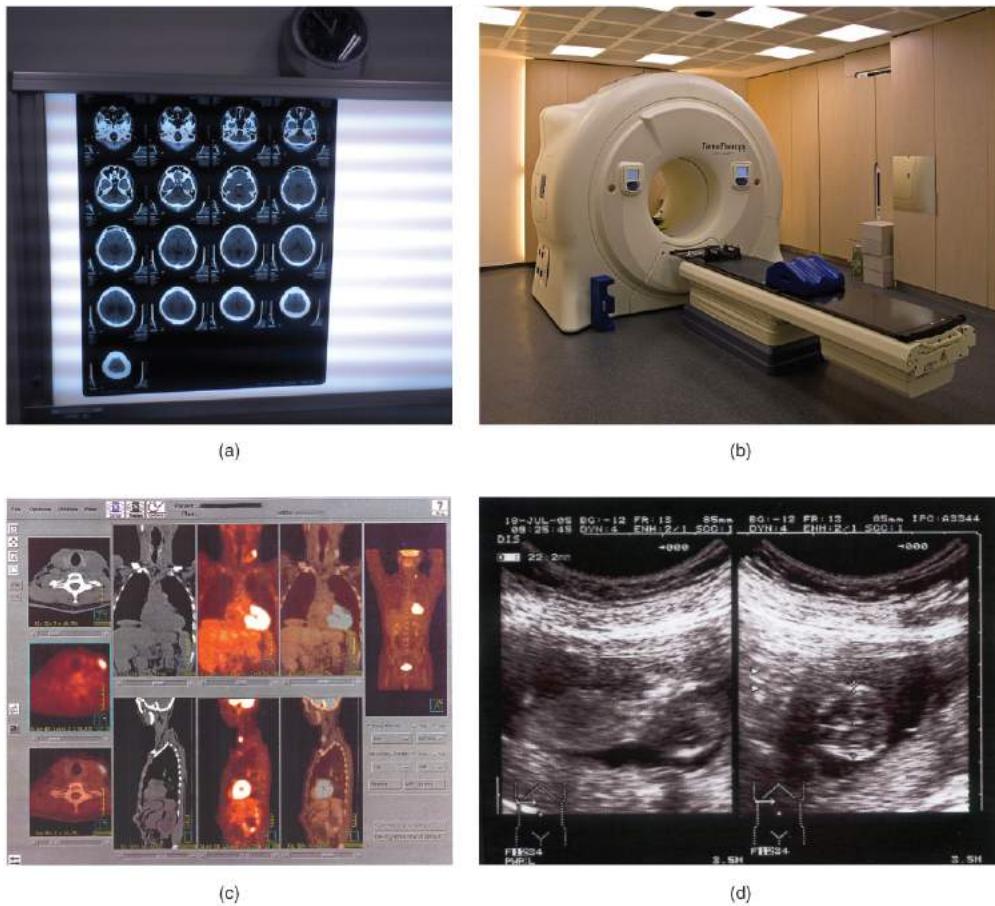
Medical Imaging Techniques: (a) The results of a CT scan of the head are shown as successive transverse sections. (b) An MRI machine generates a magnetic field around a patient. (c) PET scans use radiopharmaceuticals to create images of active blood flow and physiologic activity of the organ or organs being targeted. (d) Ultrasound technology is used to monitor pregnancies because it is the least invasive of imaging techniques and uses no electromagnetic radiation. (credit a: Akira Ohgaki/flickr; credit b: "Digital Cate"/flickr; credit c: "Raziel"/Wikimedia Commons; credit d: "Isis"/Wikimedia Commons)
